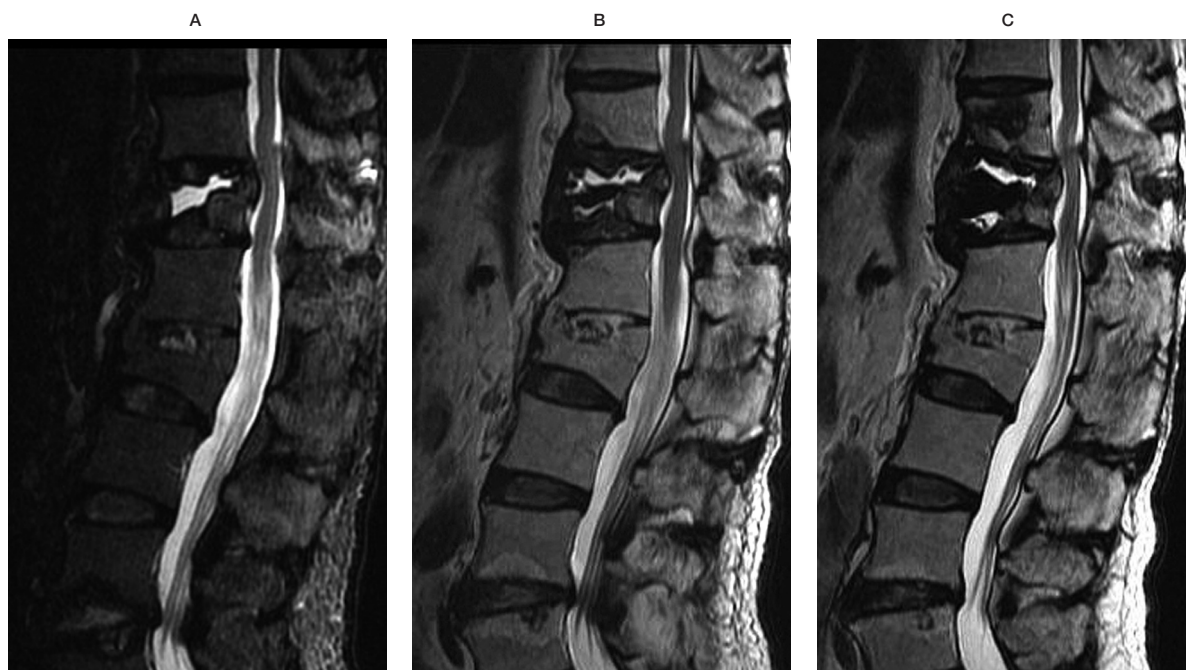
(A) A 72-year-old man had severe back pain. The STIR image showed a fluid-filled cavity in the T12 vertebral body. The bone marrow of the residual bone did not have an increased signal intensity compared to the adjacent level. He underwent percutaneous vertebroplasty (PV) and had significant pain relief at the 1 day follow-up. (B) About 36 days after the procedure, he visited the outpatient department and complained of pain and soreness over the bilateral gluteal regions. The follow-up T2W sagittal image showed fluid in the treated body. The bone marrow of the residual bone did not have a signal change. The T11 vertebral body was partially collapsed at the anteroinferior region. (C) The three month follow-up MRI after repeat percutaneous vertebroplasty showed persistent fluid collection in the interface.
